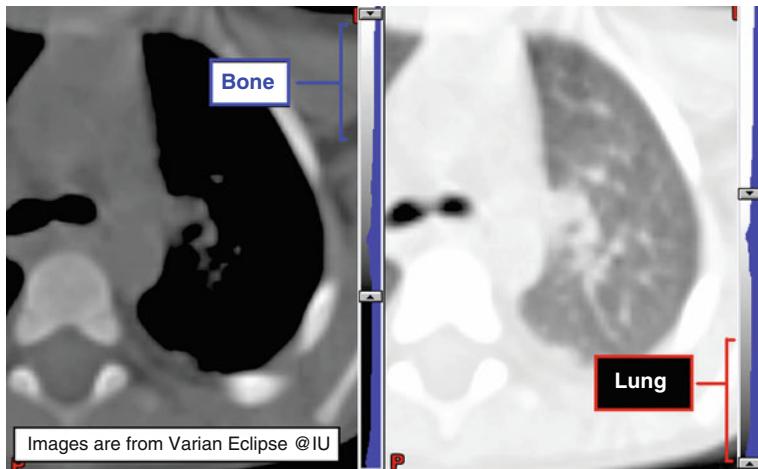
CT windows. The same CT data set can be displayed in very different ways. This example shows bone windows versus lung windows. By scrolling panel on right one can change window and level.
